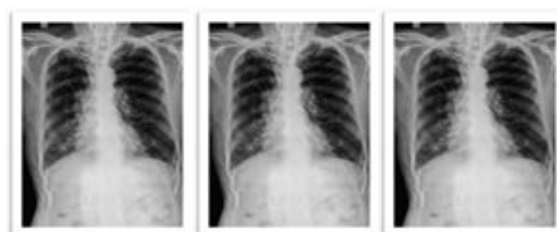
shows a chest X-ray showing Emphysematous and fibrotic changes in the right upper lobe and bilateral lower lobes, with a tracheal and mediastinal shift towards the right side
